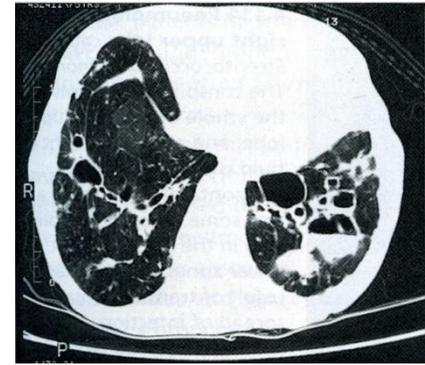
Bronchiectasis. Florid cystic bronchiectasis demonstrated on CT scanning. Fluid levels are present in grossly dilated lower lobe bronchi. CT scanning is now the imaging technique of choice in most patients with bronchiectasis.
